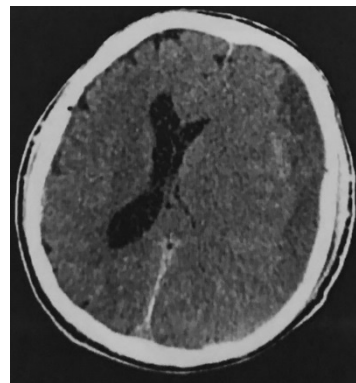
Axial CT scan of a 67 years old patient with a 13 cm AP length and a 2.5 cm thick left CSH and right midline shift
